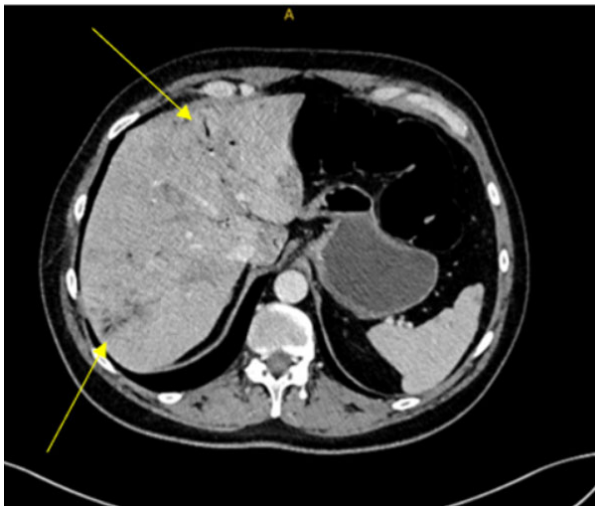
CT of the abdomen, showing portal venous gas.
